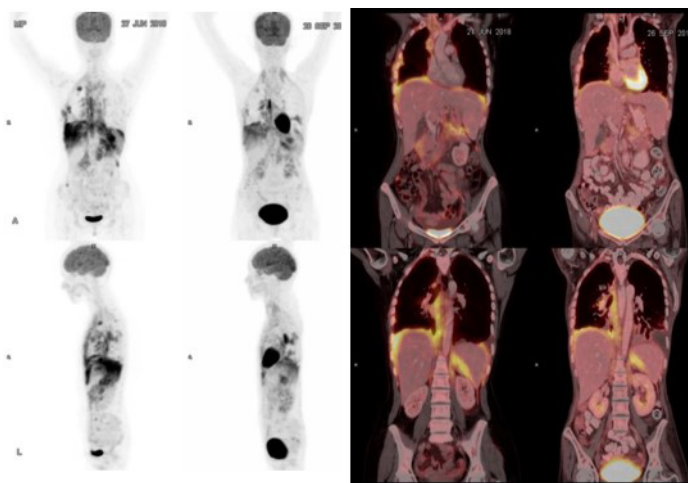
Interim PET CT – partial response
